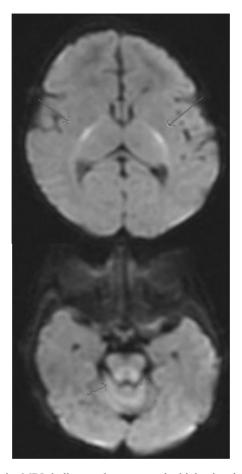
Brain MRI indicates the symmetric high signal intensity in the posterior limbs of internal capsules, suggestive of abnormal myelination.
